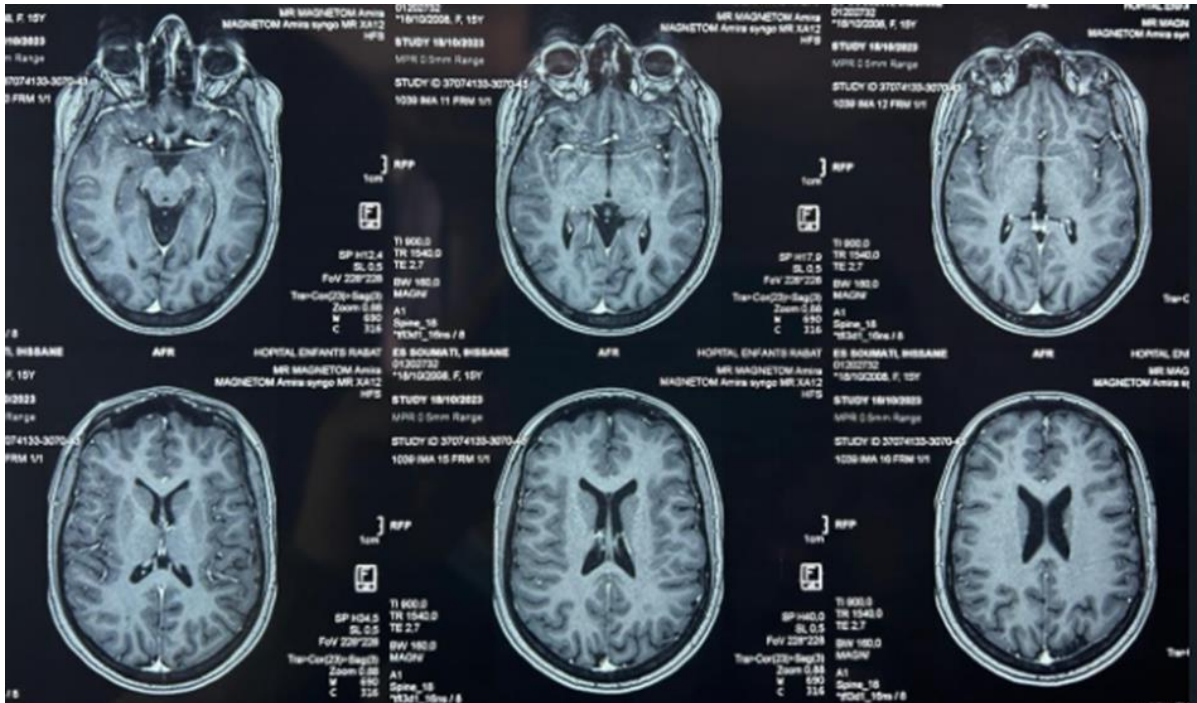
A transverse MRI scan of the brain, post-gadolinium injection, reveals diffuse moderate widening of the cortical sulci and demyelinating lesions in the deep white matter
